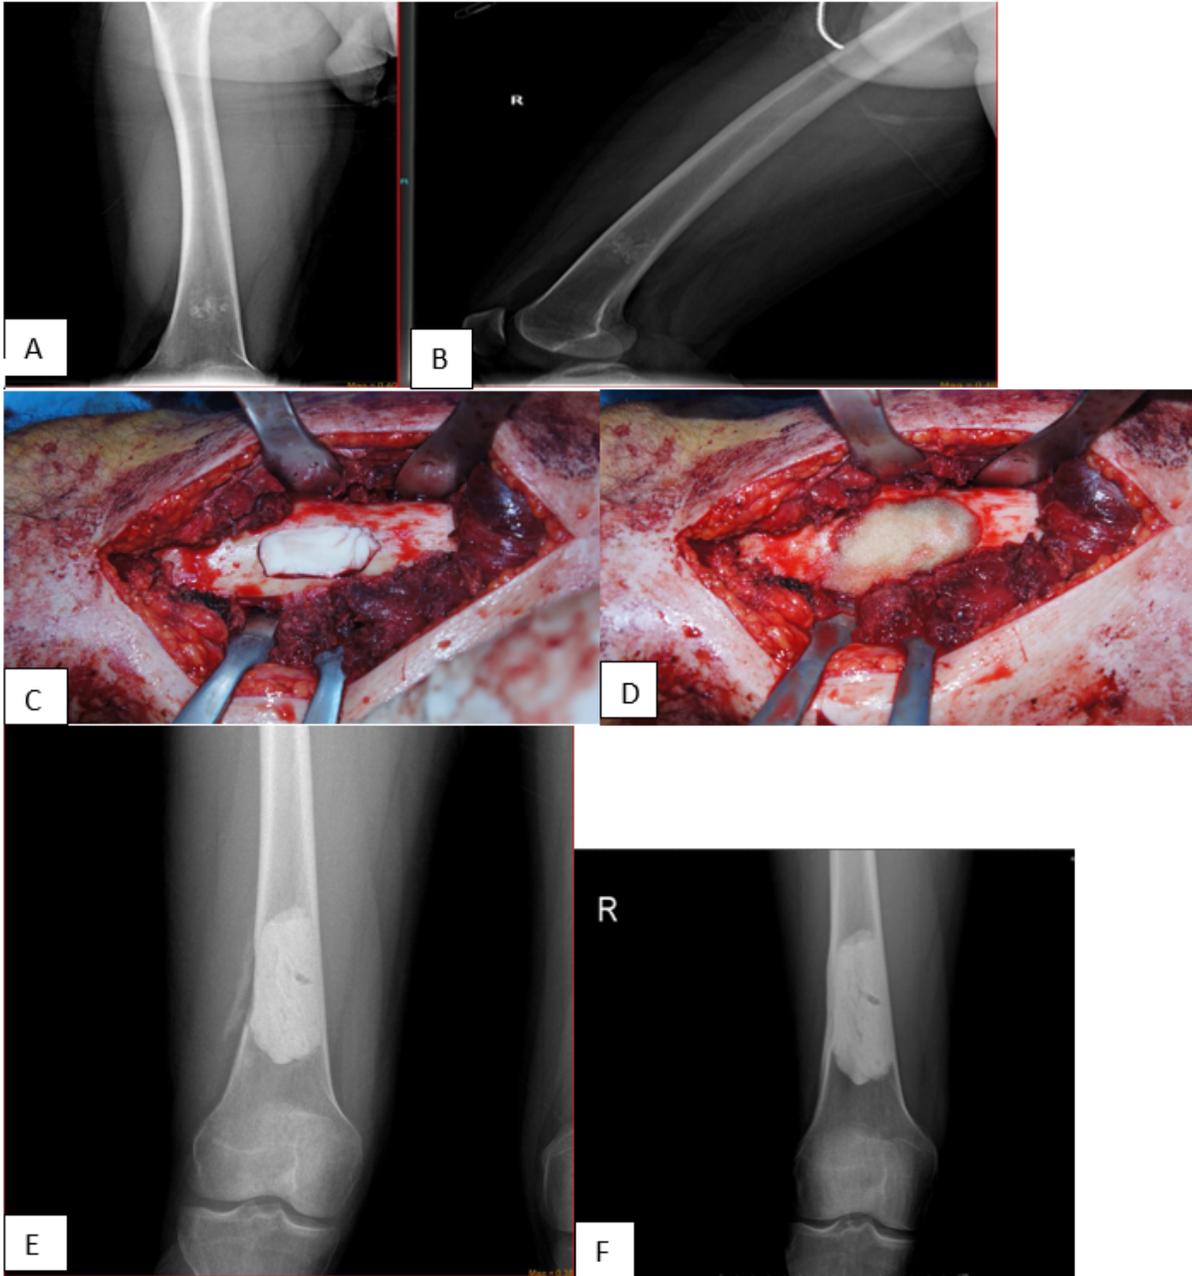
(A and B) AP and lateral x-rays of a 42 years old, male patient. (C) Curettage and cementation. (D) Putty allograft planting over the cementum. (E) Two months after the procedure. Cortical shell started to appear. (F) Three years after the index procedure. A new cortical bone formed and covered the cementum.
